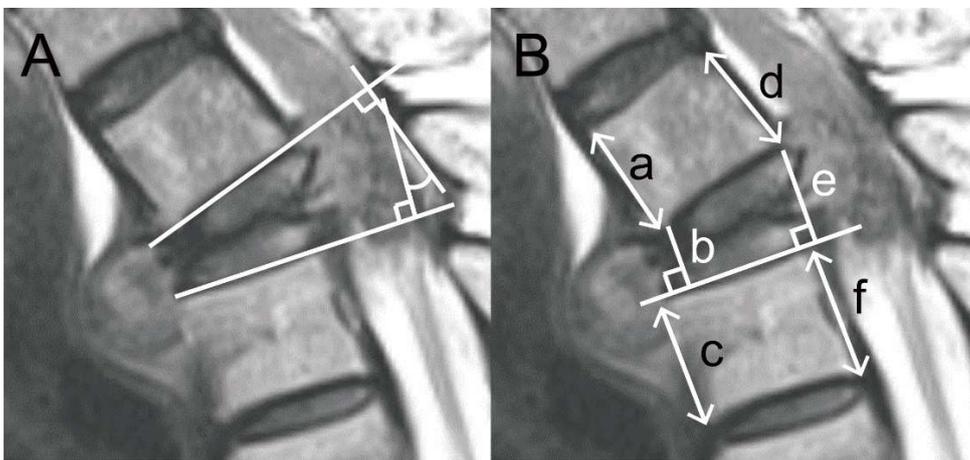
Radiological measurements using T2 weighted sagittal MRI. (A) The kyphotic angle is measured as the angle between the lower endplate of the vertebra above and the upper endplate of the vertebra below to the involved vertebra. (B) The vertebral height ratio was measured and calculated as follows: anterior vertebral height ratio = $b/((a+c)/2)$, posterior vertebral height ratio = $e/((d+f)/2)$
